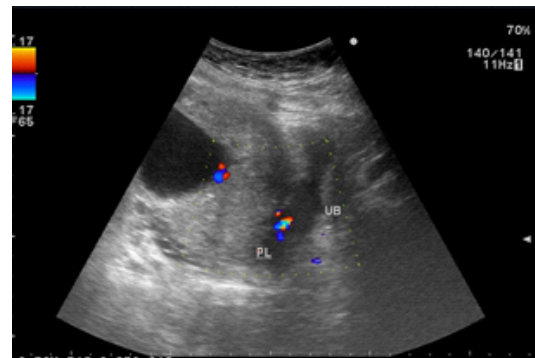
An ultrasound image in ANC with 30 weeks of gestation showing placenta completely covering internal os (complete placenta previa.)
